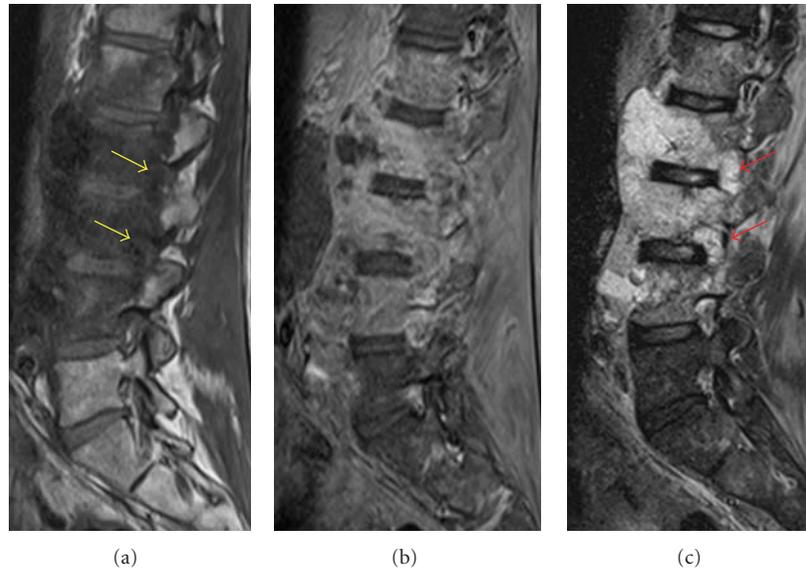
Sagittal T1-weighted MR image (a) shows abnormal hypointensity related to invasion by a paraspinous mass (spindle cell sarcoma). The cortical margins of the pedicles are attenuated (yellow arrows) in keeping with erosive changes of the mass invading through the neural foramina into the lateral epidural space. The postcontrast T1-weighted MR image with fat-saturation (b) shows heterogeneous enhancement of the mass. Marrow infiltration and neuroforaminal involvement (red arrows) is well seen as hyperintense signal on the STIR MR image (c).
